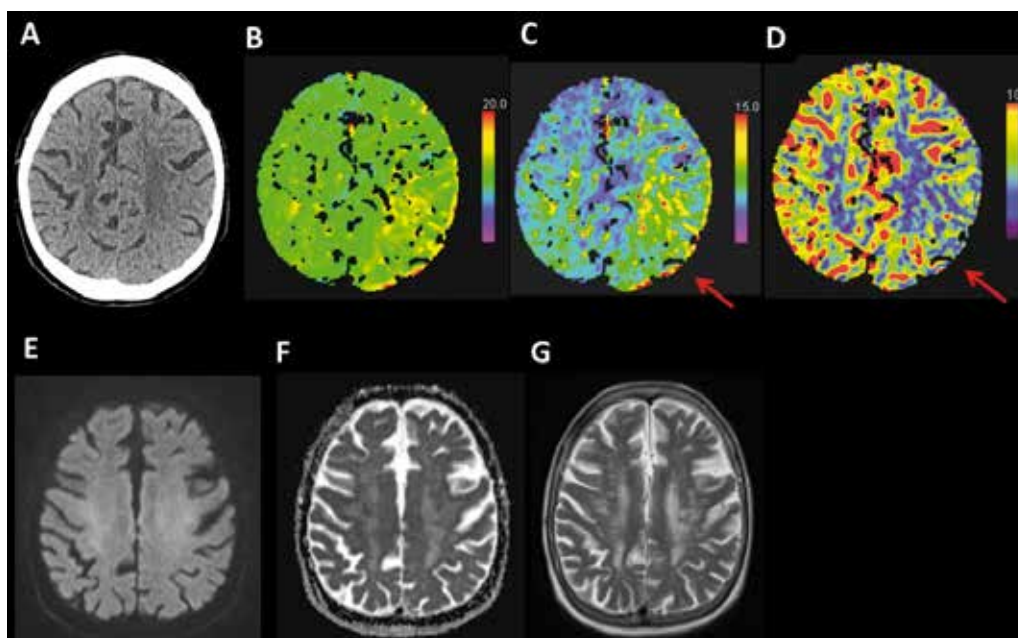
91 year old female in postictal state after prolonged generalized tonic-clonic seizure with acute hemiparesis on the right for 3h, GCS 7. EEG showed slowing on the left hemisphere. A- CT nativ without abnormality, B-D hypoperfusion of the left parietal hemisphere with B- prolonged TTP (time to peak), C- prolonged TTD (time to drain), and D- decreased CBF (cerebral blood flow). E-G follow-up MRI one day later: no diffusion restriction, leukencephalopathic changes within the white matter. Postictal hypoperfusion is observed particularly in patients with postictal focal deficits (Todd's paresis or aphasia). Perfusion changes are most easily seen on maps of contrast transition times (TTD, mean transit time (MTT) or TTP). We note a diffuse cortico-subcortical pattern and a spatial distribution not corresponding to vascular territories.
